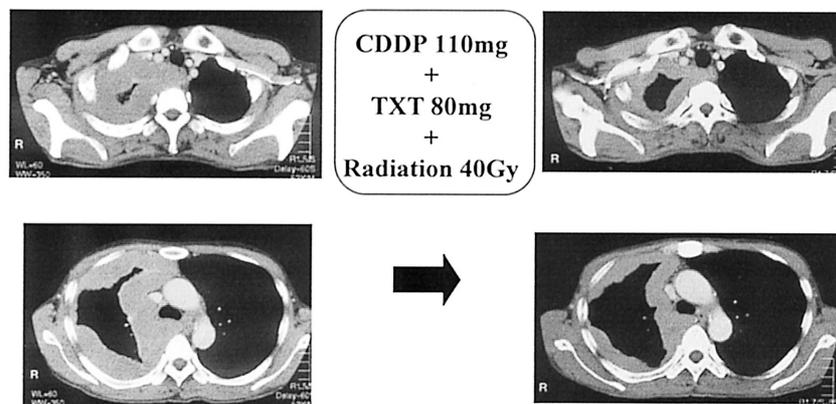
The findings of the chest CT scan of the case No. 6 before and after induction therapy.
